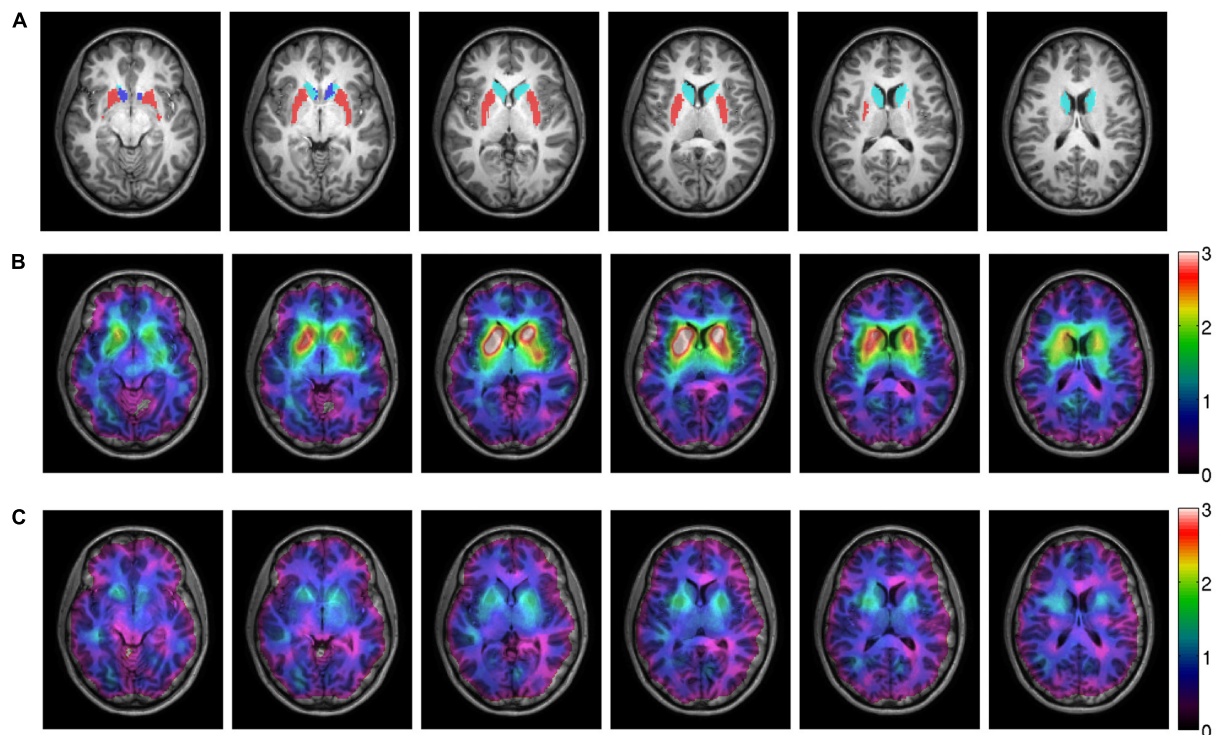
MRI and SPECT images of one patient, treated with 300 mg amisulpride displaying a mean dopamine D_2 receptor occupancy of 56%. Panel (A) shows the sMRI image with the caudate nucleus (light blue), putamen (red) and accumbens (dark blue) from the subcortical Harvard-Oxford atlas depicted. Panels (B,C) show the co-registered SPECT image on top of the MRI image. The color scale corresponds to the specific binding potential before treatment (B) and after six weeks of treatment (C).
